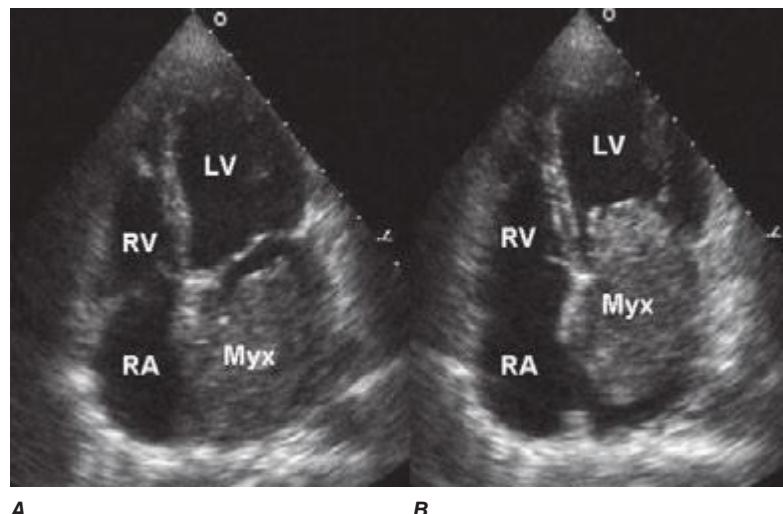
1 Transthoracic echocardiogram demonstrating a large atrial myxoma. The myxoma (Myx) fills the entire left atrium in systole (A) and prolapses across the mitral valve and into the left ventricle (LV) during diastole (B). RA, right atrium; RV, right ventricle. (Courtesy of Dr. Michael Tsang; with permission.)
